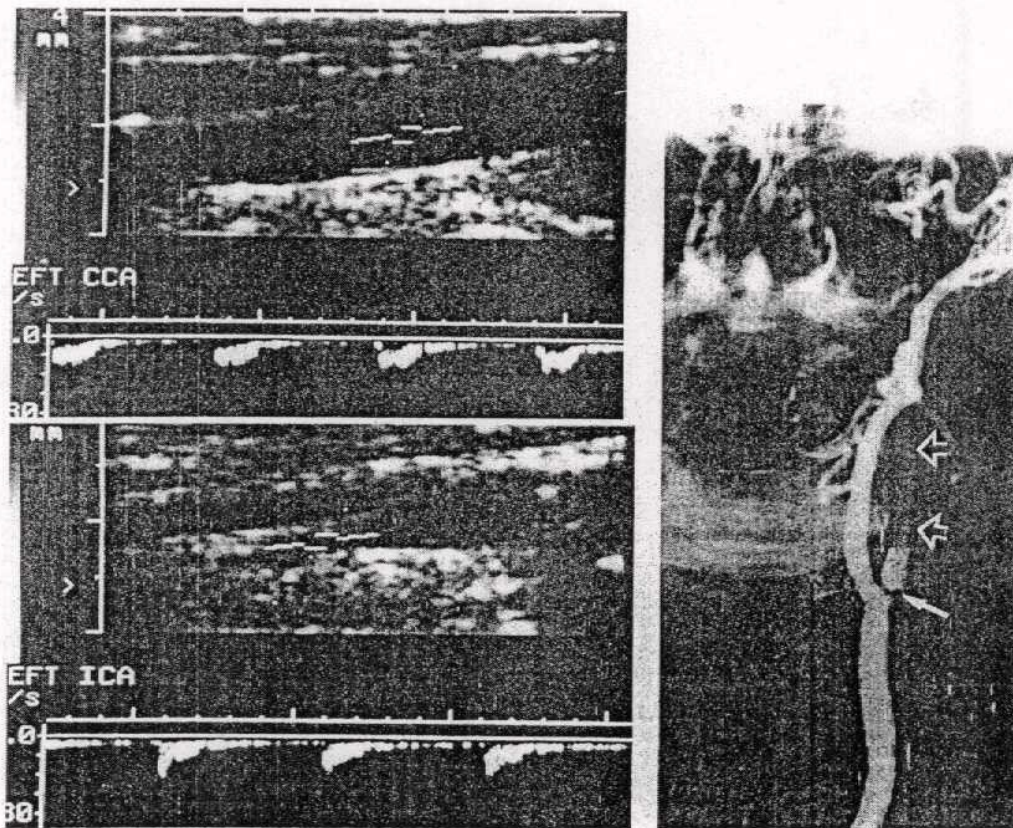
High-grade stenosis producing decreased peak velocity with elevated resistance. (a) CCA demonstrates decreased diastolic flow (increased resistivity index), also known as externalization of flow. (B) ICA shows similar externalization pattern in narrowed vessel. (C) Angiogram demonstrates critical stenosis at the origin of the ICA (arrow). (*Quoted from, Diagnostic ultrasound, 1998*).
